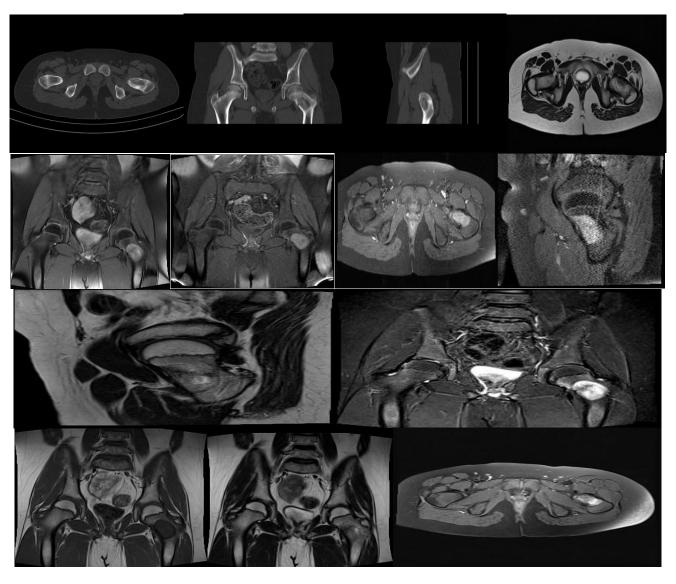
CT and MRI images of fibrous dysplasia arising from the neck of the left femur.
